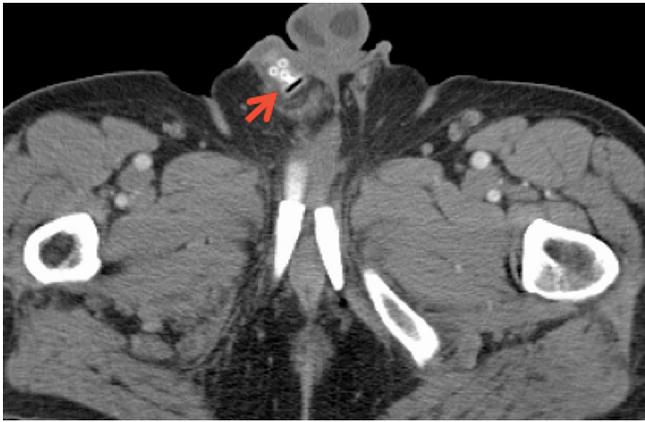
Axial CT image demonstrates cephalad pump migration (red arrow), adjacent to the penile shaft base. Expected pump location is in the midline within the scrotum.
